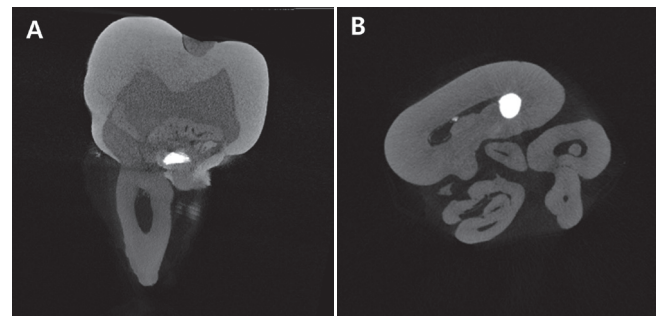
Micro-computed tomographic appearance of the maxillary permanent first molar of patient 2. (A) Bucco-lingual section. Mineralized layer of the maxillary first molar was observed at mid-height of the crown. Enamel fissure at the plate region and irregular protrusions of enamel at the cervical region were observed. (B) Horizontal section. Several dysplastic roots were twined, leading to highly irregular canal morphologies.
